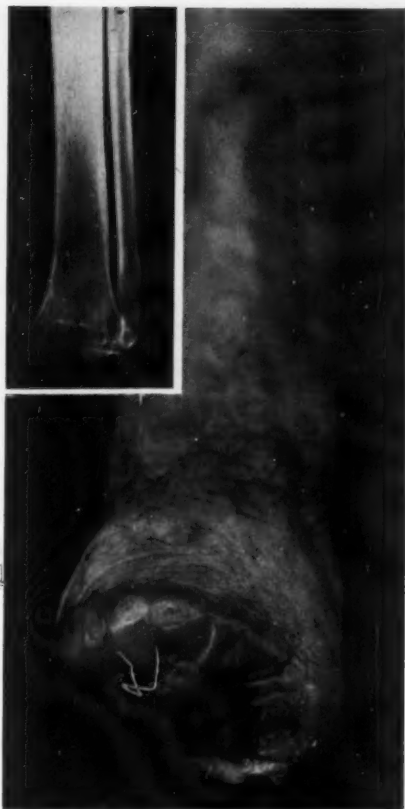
A modified Syme amputation in which, because of an injury that completely destroyed the heel flap and the calcaneus, the transected ends of the tibia and fibula were covered with a flap from the dorsum of the foot. Photo shows stump 10 years after amputation, never any trouble; insert is a radiograph showing broad area of support, which probably accounts for the success of this stump despite lack of covering with normal heel pad. Similar to Baudens' supramalleolar amputation (2).
